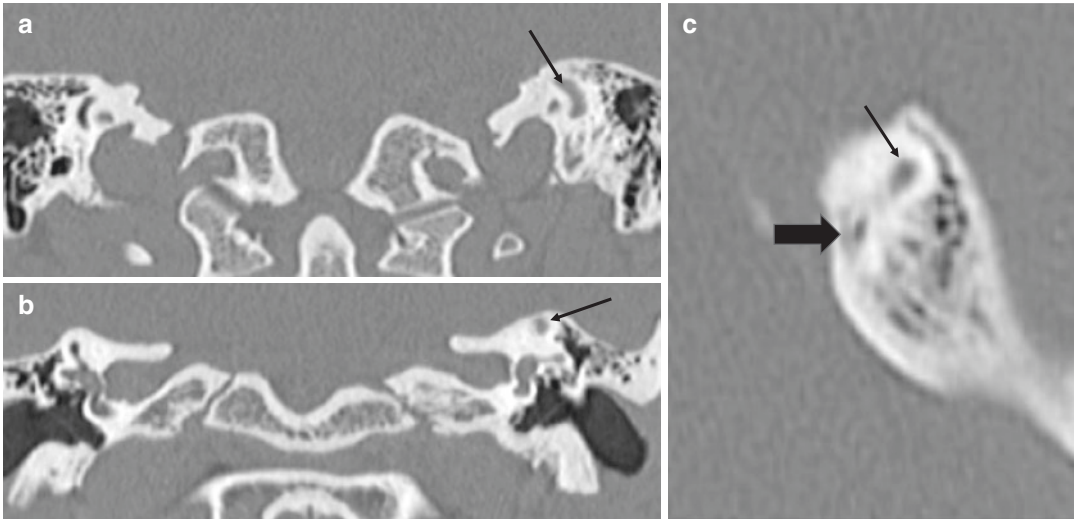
(a, b) Coronal temporal bone CT and (c) axial CT of the left petrous temporal bone. The left semicircular canals (thin black arrows) are expanded with a subtle surrounding halo of lucency (thick black arrow)
